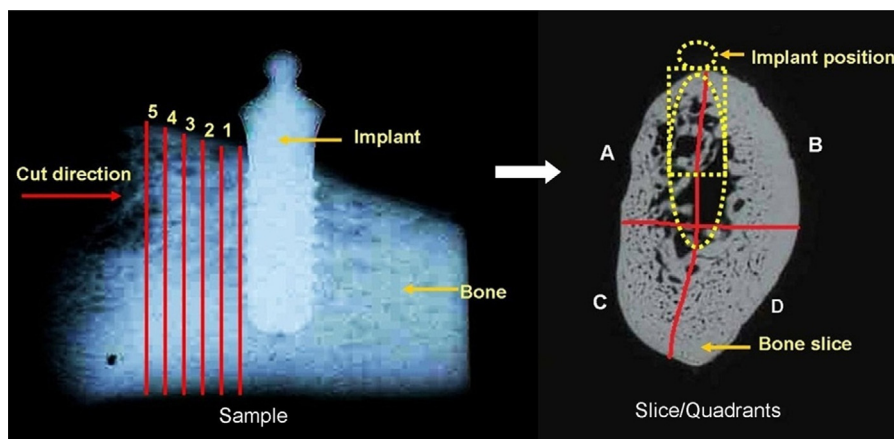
Scheme (X-ray image) of the cutting procedure for samples 1–7: at least five bone slices were obtained from each sample; each slice was divided into 4 quadrants (A, B, C and D). The red lines represent the cuts, and the distance between two cuts is 1 mm, the numbers represent slice numbers, number 1 represents the slice closest to implant. (For interpretation of the references to colour in this figure legend, the reader is referred to the web version of this article.)
